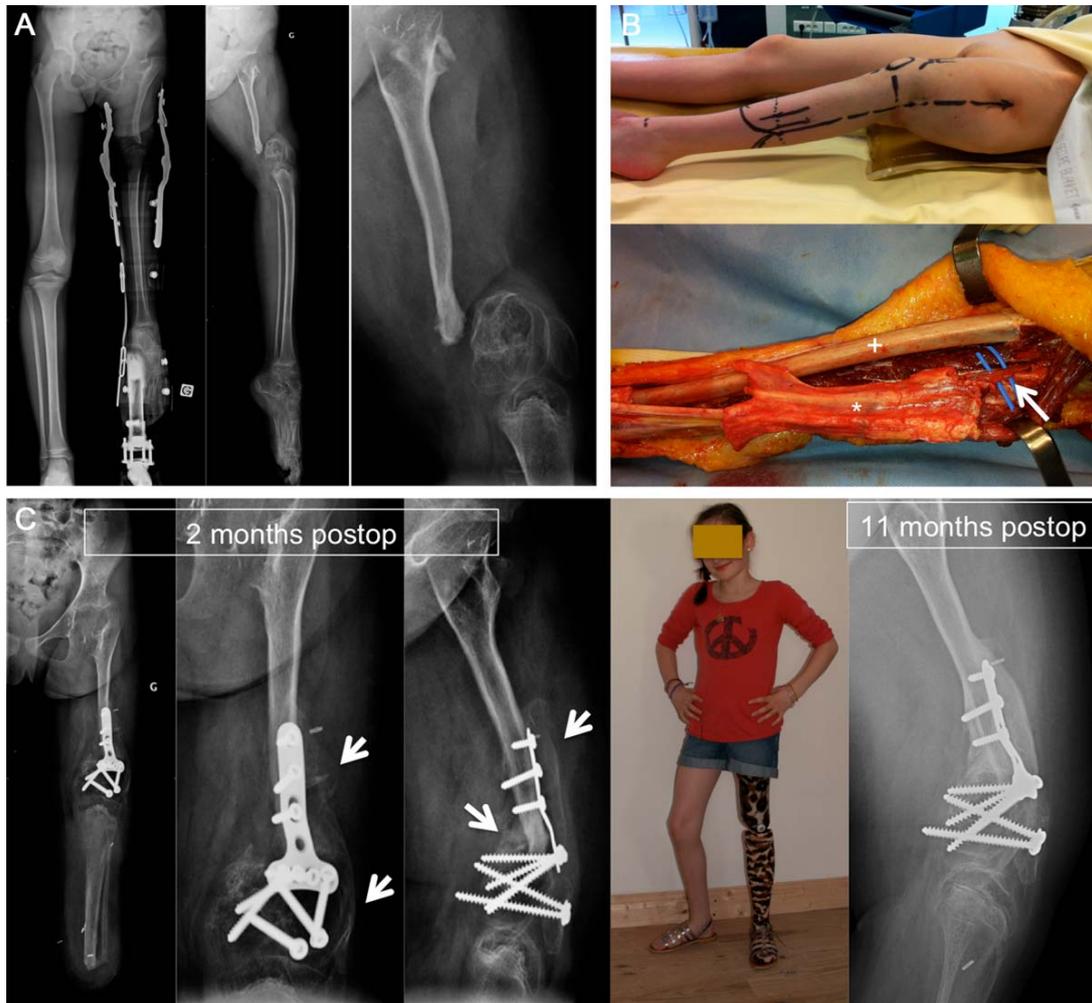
A: Post-infectious hypoplastic femur with severe limb length discrepancy associated to a supracondylar femoral recalcitrant nonunion needing an ischial bearing prosthesis. B: Intraoperative images showing the marked surgical incisions (above). A VTPG (*) pedicled proximally on the ATV (arrow) was obtained from the tibia (+) before amputation. C: Radiographs showed a completely ossified large callus and a complete femoral supracondylar nonunion healing two months postoperatively (arrow) allowing to walk early with a femoral weight-bearing prosthesis. Eleven months postoperatively the radiographs showed a complete callus ossification and remodeling.
